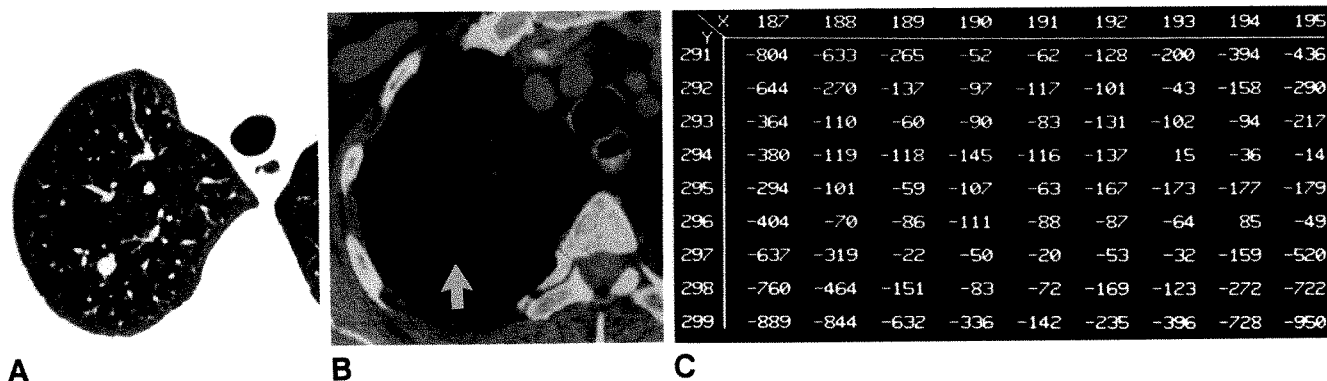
A, High-resolution CT scans with lung window settings in patient with a small nodule detected on plain films. B, With mediastinal window settings, nodule (arrow) appears to be of a density similar to that of subcutaneous fat. C, CT numbers measured from this nodule indicate it is entirely or almost entirely fat. Hamartomas can have this appearance. This lesion was followed up with plain radiographs and remained unchanged in size.
